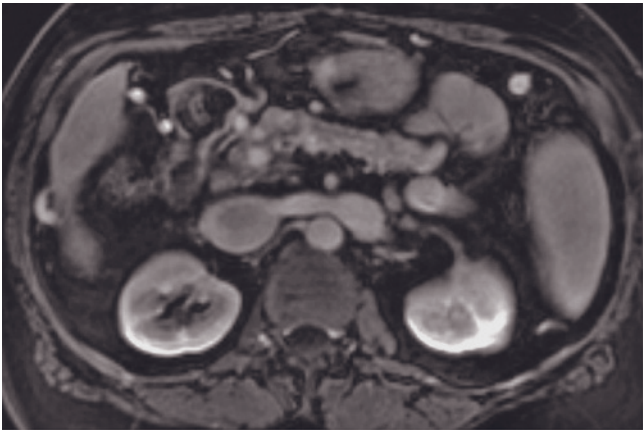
Splenomegaly secondary to portal hypertension, splenorenal shunt, and splenic artery aneurysm. Coronal T1-weighted SGE (*a*), coronal T2-weighted echo-train spin-echo (*b*), immediate postgadolinium T1-weighted SGE (*c*), and 90-s postgadolinium fat-suppressed SGE (*d*) images. Massive splenomegaly is demonstrated on all MR images. No focal lesions are present on precontrast T1 (*a*) or T2-weighted (*b*) images. The presence of arciform enhancement on the immediate postgadolinium SGE image (*c*) excludes the presence of malignant disease. At 90 s, the spleen becomes homogeneous in signal (*d*). T1-weighted delayed postgadolinium 3D-GE images (*e, f*) demonstrate splenomegaly, splenorenal shunt, and portosystemic collaterals in another patient with portal hypertension. Axial T1-weighted 45-s postgadolinium fat-suppressed 3D-GE images (*g, h*) and coronal reformatted 3D-GE
